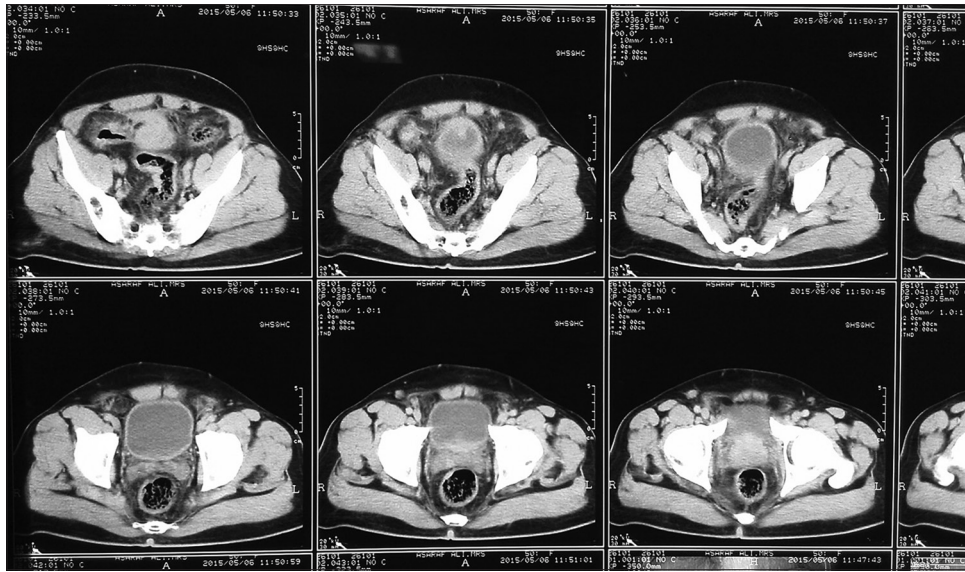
Computed tomography of the abdomen showing an irregular mass seen superior to fundus of urinary bladder appearing adherent to mesentery and bowel loops
